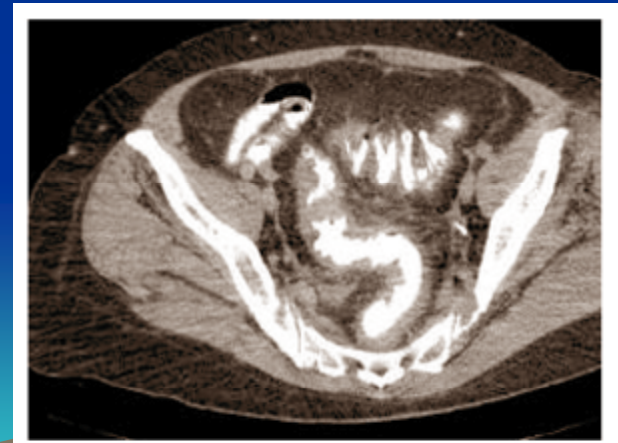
Inflammation of the colon. Abdominal CT scan with contrast showing pancolitis.
